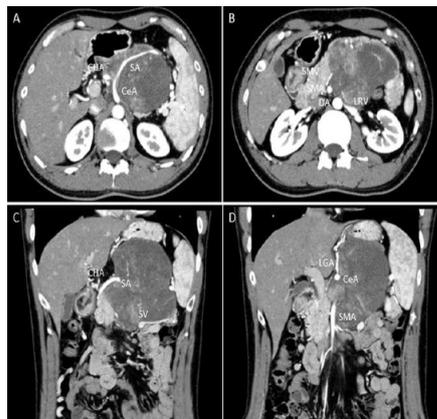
Abdominal computed tomography images in axial (a, f) and coronal (b, c) views show a huge lobulated mass of 11 cm in diameter, with a well-circumscribed capsule on the pancreatic body. a Approximately 270° of the celiac artery (CA) and 360° of the splenic artery (SA) were surrounded by the tumor. b The common hepatic artery (CHA) was contacted for a distance 26.6 mm by the tumor and compressed to the upper side of the abdomen (arrow). c The superior mesenteric artery (SMA) was contacted for 42.8 mm and was compressed to the right side (arrow). d CT angiography showed the narrowing and irregularity of the SA.
